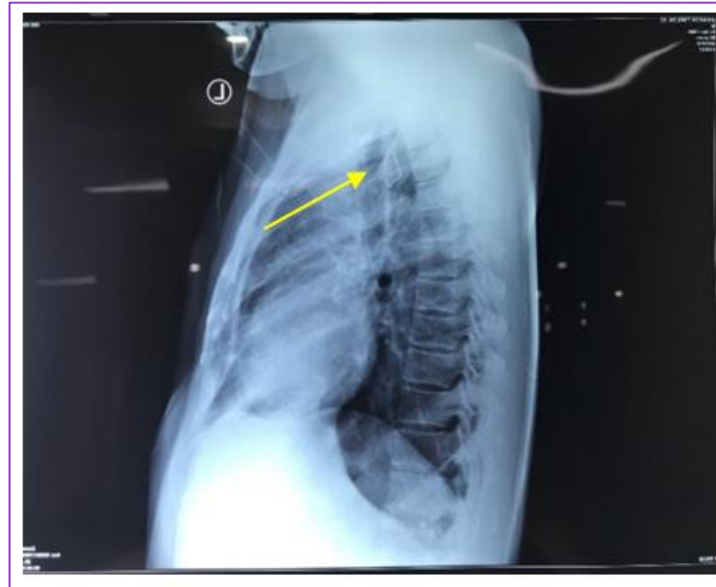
Foreign bodies as high as T3-4 appear on lateral thoracic X-rays
